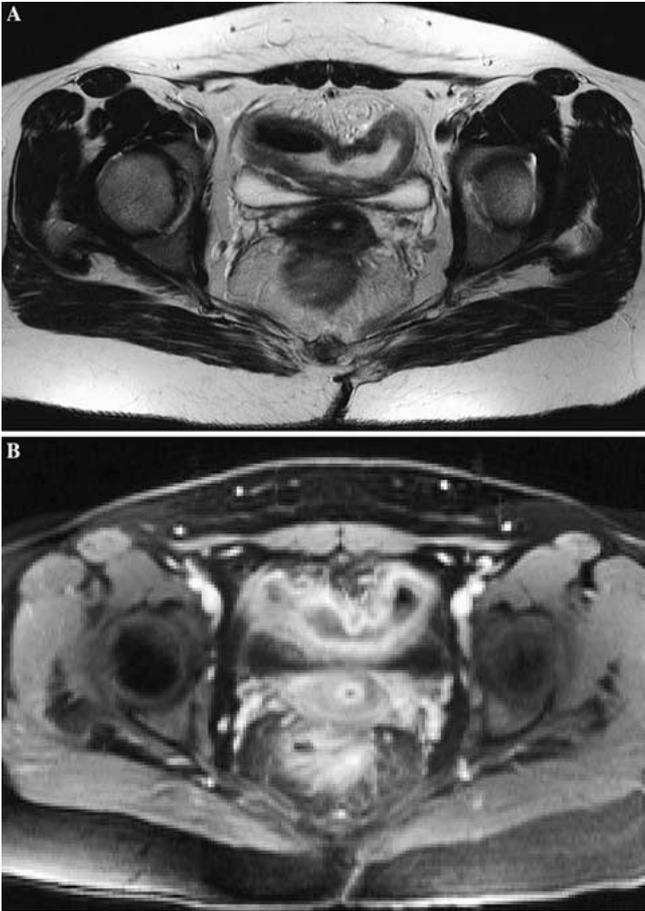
Sigmoid colon in a 20-year-old female with CD and clinical signs of severe inflammation. A Axial T2-weighted turbo spin-echo image shows marked wall thickness of the sigmoid colon. B Axial T1-weighted fat-suppressed gadolinium-enhanced fast low-angle single-shot image shows marked wall thickening with evident irregularities of the outer border that are likely related to inflammatory adhesions, a distinctive sign of CD.
